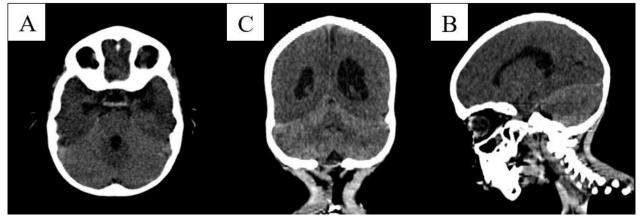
Cerebral CT scan in axial (A), coronal (B) and sagittal (C) sections demonstrating diffuse reduction in the density of the supratentorial brain parenchyma with loss of normal grey-white matter interface in keeping with severe oedema, associated with comparatively increased density of brainstem and bilateral cerebellar hemispheres
